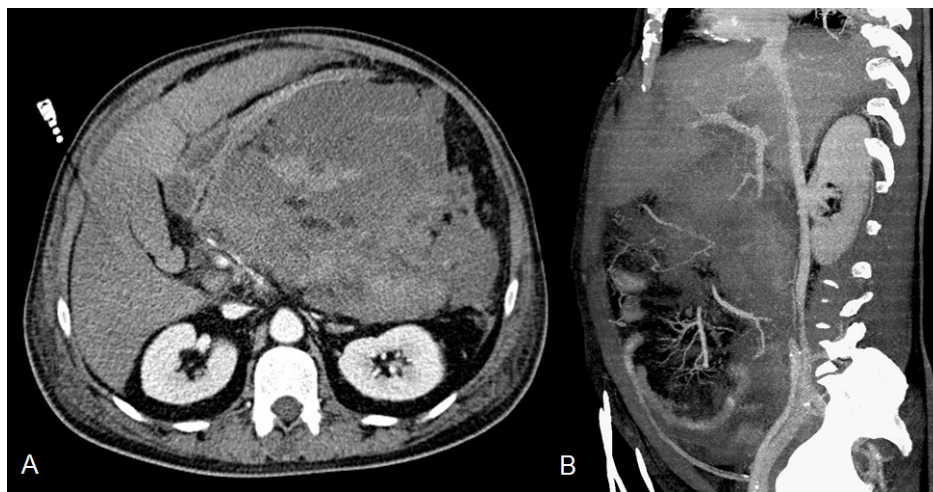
Abdominal CT scan. A. Extra-pancreatic and acute hemorrhagic collections, gastric compression and collapse, severe hepatic artery stenosis and splenic parenchymal and left liver lobe hypodensities (visceral infarctions). B. Loss of normal pancreatic anatomy and inflammation containing the arterial tree and porto-spleno-mesenteric venous trunk.
